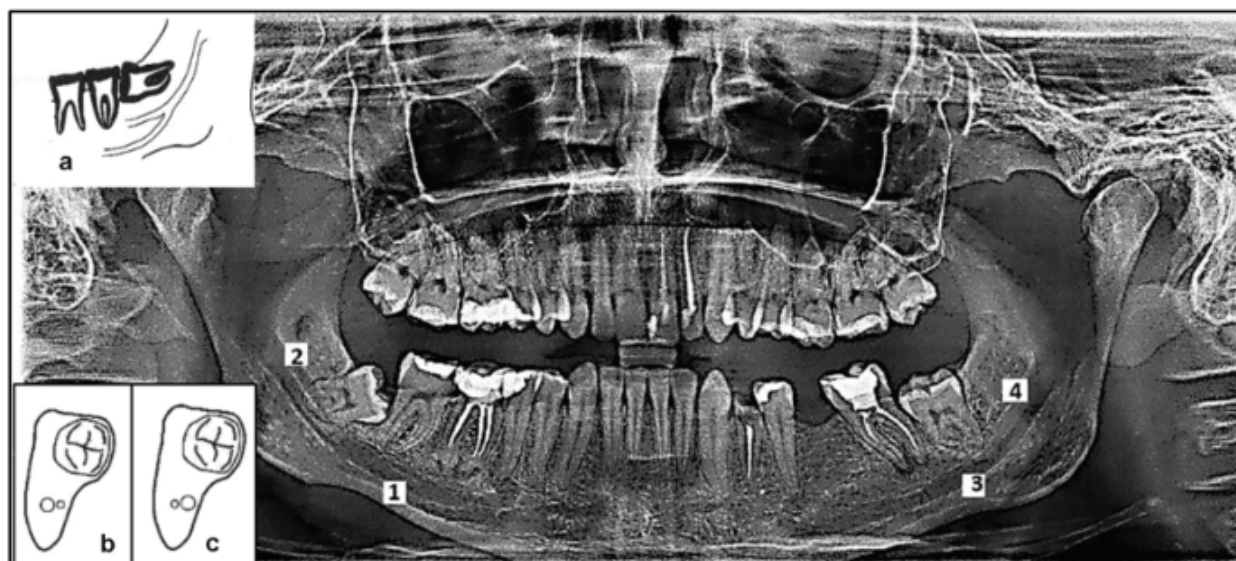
Additional mandibular canal (X-ray panorama of a 58-year-old woman). 1 – right mandibular canal; 2 – right additional mandibular canal; 3 – left mandibular canal; 4 – left additional mandibular canal; a, b, c – types of parallel additional mandibular canal according to Naitoh's classification; a – parallel additional mandibular canal type; b – additional parallel canal type located inside the molar roots; c – additional parallel canal type located outside the molar roots.
